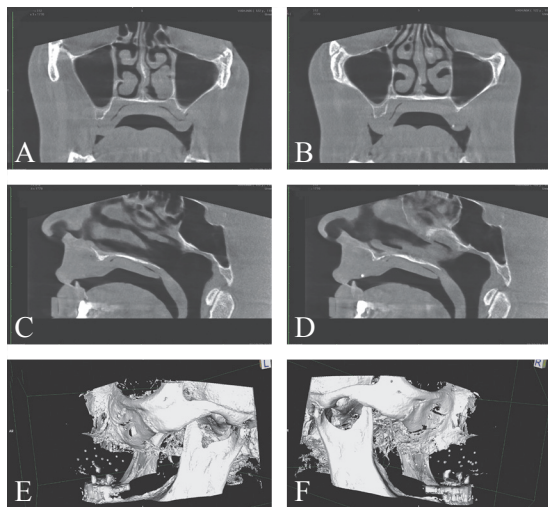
Cone Beam Computed Tomography (CBCT) evaluation for treatment planning. The different projections (A-D) show the severe bone atrophy of the upper jaw. The 3D reconstruction of the bone anatomy of the upper jaw (E, F).
